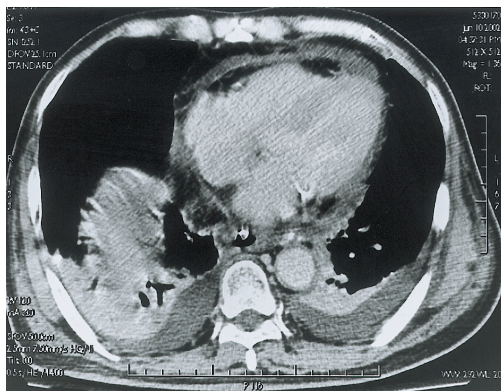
Chest CT shows fluid collection and infiltration in the mediastinum with bilateral pleural fluid collection and thickening of the pericardium.
